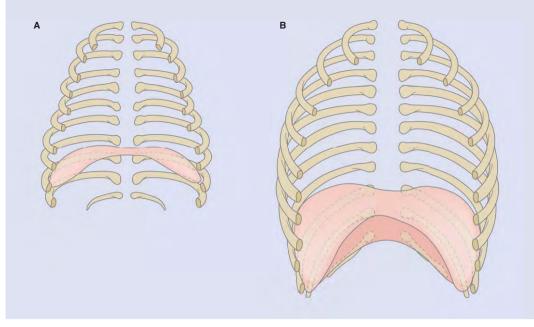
Area of costal apposition of the diaphragm in newborn (A), and adult (B). (Redrawn from Devlieger H, Daniel H, Marchal G, et al: The diaphragm of the newborn infant: Anatomic and ultrasonographic studies. J Dev Physiol 16:321-329, 1991.)
